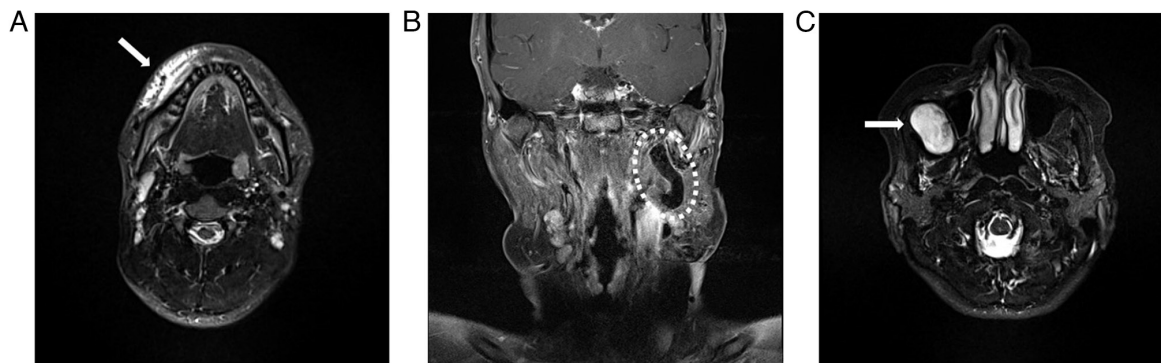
Shape categories of the vascular anomalies. (A) An axial STIR MR image, demonstrating markedly hyperintense dense small capillaries (white arrows) in the lower right buccal area. (B) A coronal T1-weighted MR image, demonstrating a hypointense serpiginous vessel (dashed circle) in the left maxillofacial area. (C) An axial STIR MR image, demonstrating a hyperintense mass (white arrows) in the right buccal area. MR, magnetic resonance; STIR, short tau inversion recovery.
